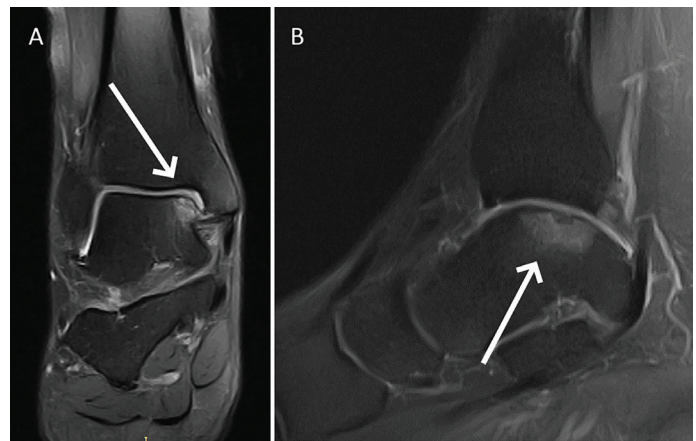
MRI of the patient's 4 right ankle with osteochondral defect of the talus bone (white arrow), frontal (A) and sagittal (B) side
